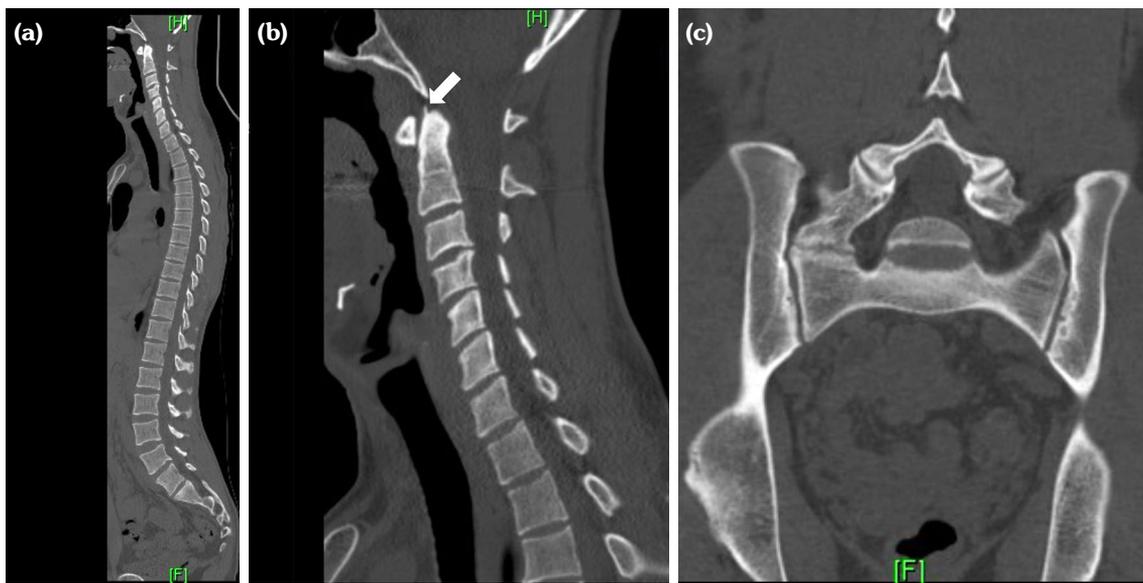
Computed tomography images of (a) whole spine, (b) syndesmophyte on odontoid process of C2 (white arrow), and (c) sacroiliac joint.
